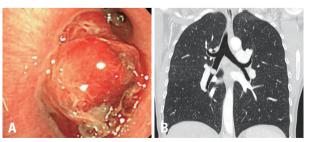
Bronchoscopic examination of a typical carcinoid shows a round shape, lobulated surface, pinkish color, visible vessels on the tumor surface. Spontaneous bleeding was frequent (A). Chest computed tomography shows a 20-mm round nodule at the right bronchus intermedius (B).
